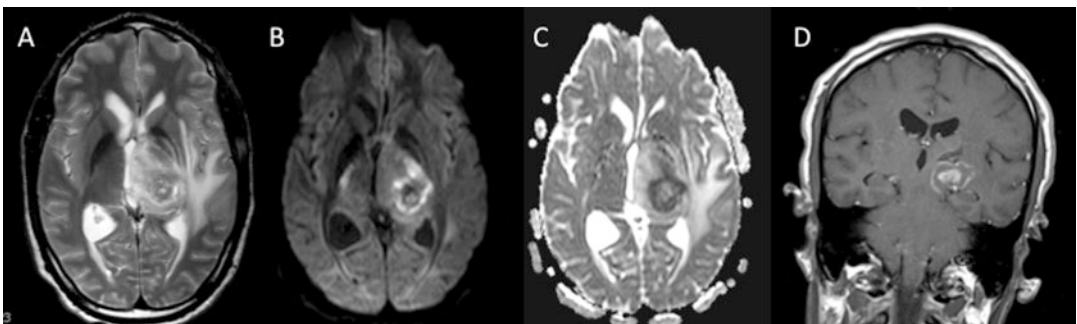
Tumor mimic: toxoplasmosis. T2w (a), b1000 DWI (b), ADC map (c), and T1 + Gad (d) images in a middle-aged male showing a thalamic mass with restricted diffusion and dual rim enhancement (“target sign”). The
